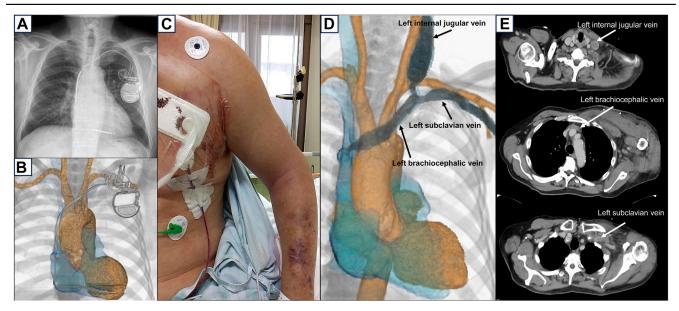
Physical and examination findings of the patient before and after the cardiac implantable electronic device extraction. A: Chest radiography on admission. B: This shows the 3-dimensional (3D) constructed computed tomography (CT) image on admission. The orange depicts the arterial vessels, and the light blue depicts the venous vessels. C: Significant swelling of the upper extremity deep venous thrombosis the day after the cardiac implantable electronic device extraction. D: This shows the 3D-constructed image of a thrombus by contrast-enhanced CT. Orange depicts the arterial vessels, light blue depicts the venous vessels, and dark gray depicts the thrombus in the veins. A thrombus is seen from the left brachiocephalic vein to the internal jugular and subclavian vein. E: Thrombosis detected by contrast-enhanced CT in the left internal jugular, brachiocephalic, and subclavian veins (arrow).
